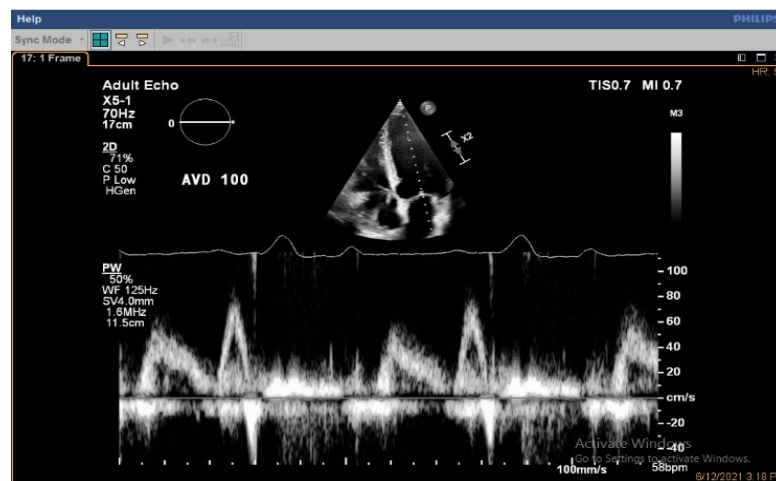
Pulsed Wave Doppler on mitral valve of optimum AVD of case number
